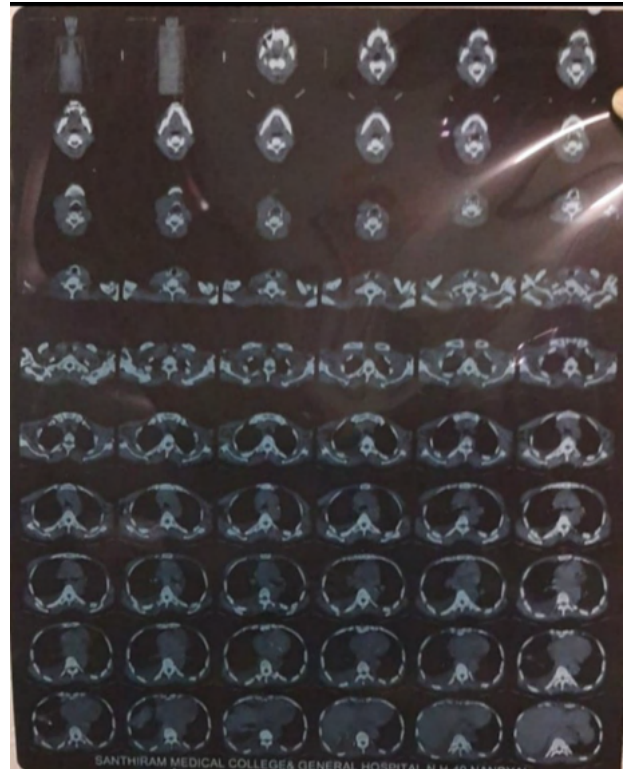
CT scan of chest
